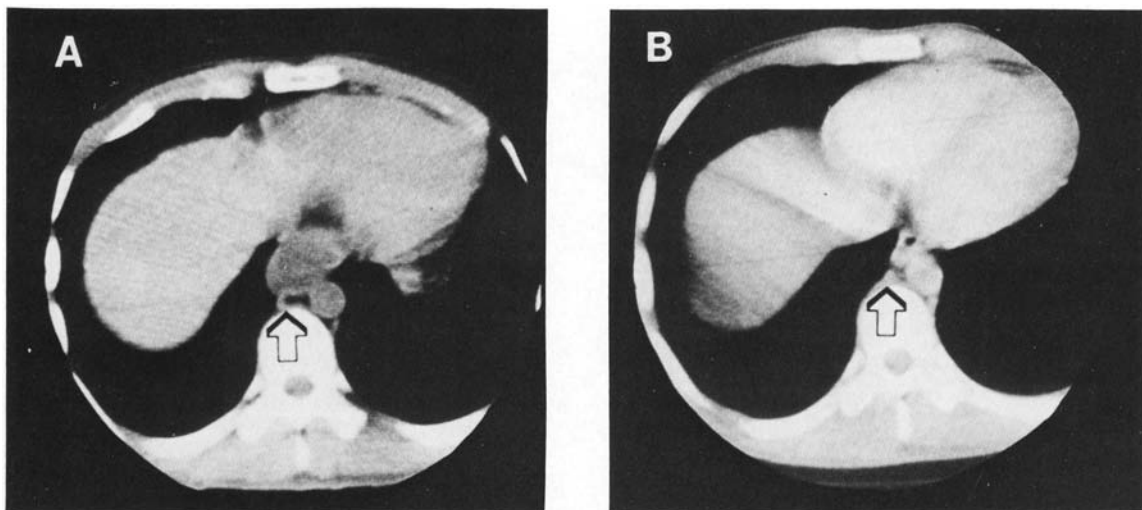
Chest CT scans of patient no. 5 show mediastinal metastases of malignant melanoma. (A) Before 3F8 treatment; arrows point to sites of disease. (B) After 3F8 treatment.
